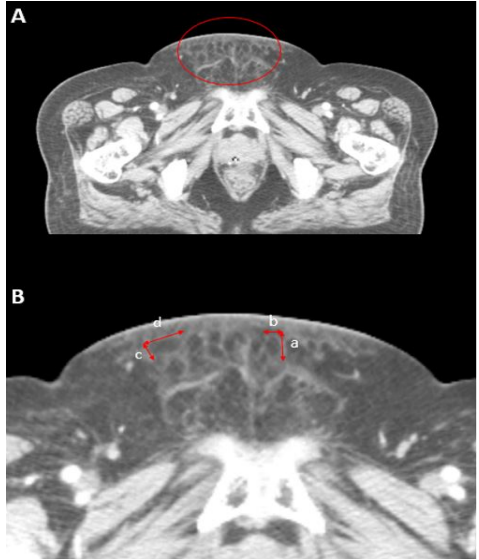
Representative CT images of "honeycombing" and "taller than wide" appearance: (A) The circle contains both the "honeycombing" and "taller than wide" appearances. (B) An enlarged image of the area enclosed by the box in (A). The height of the fat lobule is measured as "a" and its width as "b.". Perineum in which the a/b ratio is >1 are defined as having a "taller than wide" appearance (positive). In contrast, perineum in which the ratio is lower <1 (e.g., -c,d) are defined as having a "wider than tall" appearance (negative).
